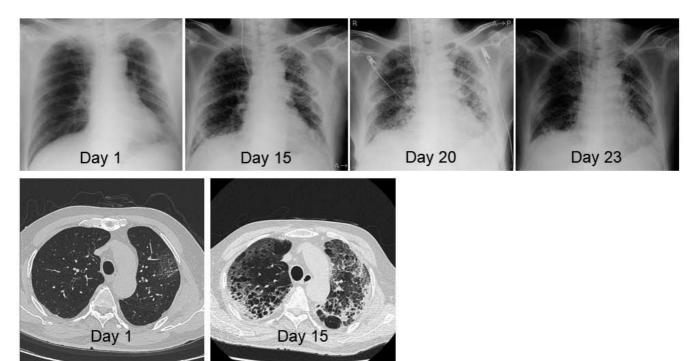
Serial chest X-ray and high-resolution computed tomography images of the patient.
